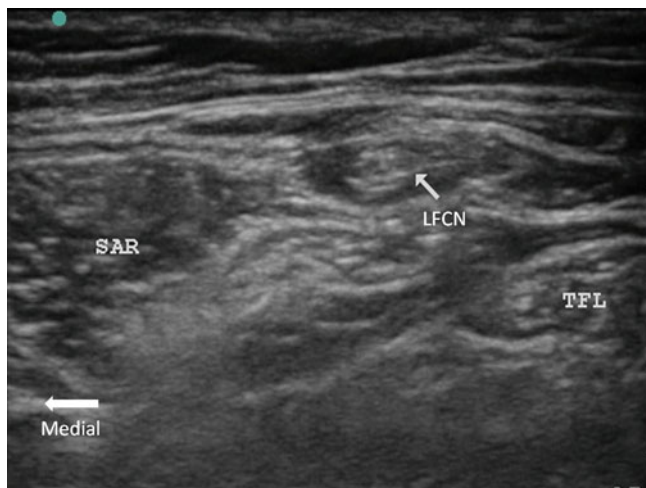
The ultrasound appearance of the LFCN in a patient with meralgia paresthetica. The nerve appears large and swollen, embedded in the adipose tissue in the groove formed by the tensor fascia lata (TFL) and sartorius (SAR) (Reproduced with permission from Philip Peng Educational Series)
